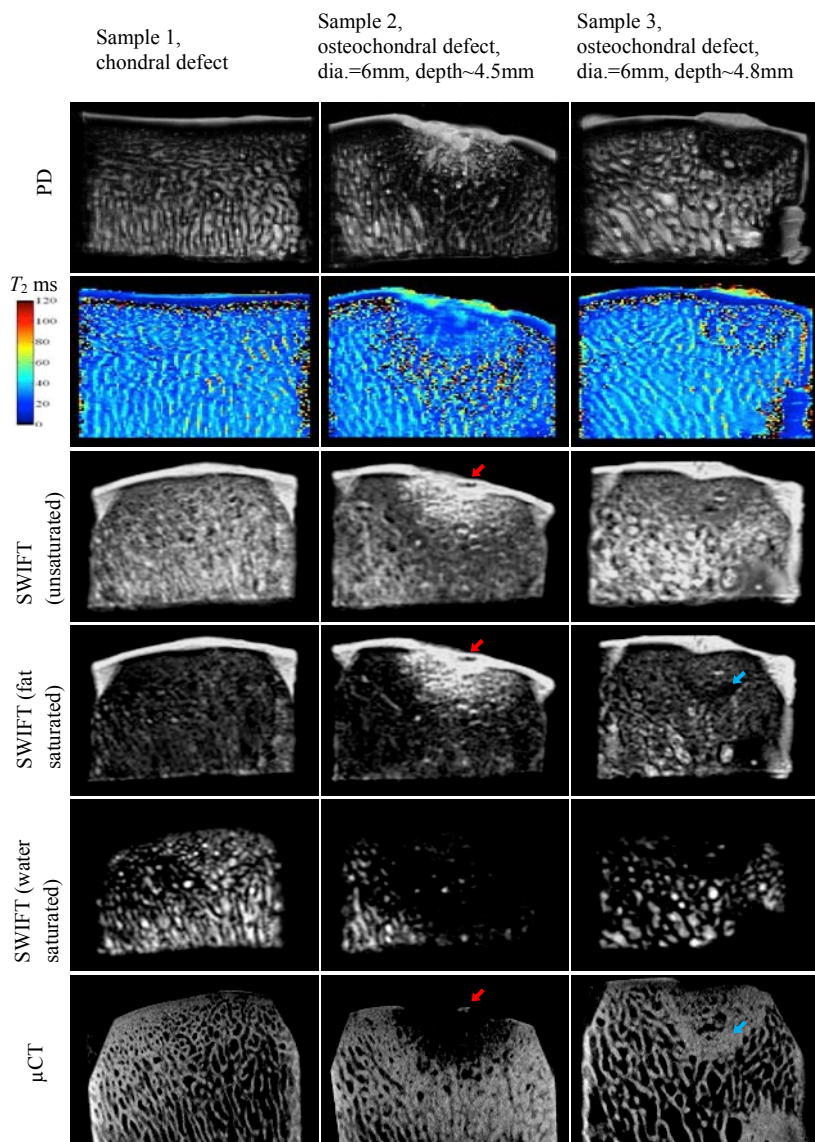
Proton density weighted images, T_2 relaxation time maps, unsaturated SWIFT images, SWIFT with fat saturation and water saturation and μ CT images of three representative cases with chondral and osteochondral lesions. The SWIFT images and μ CT images were re-sliced from the 3-D data set to the same location using surgical landmarks.
